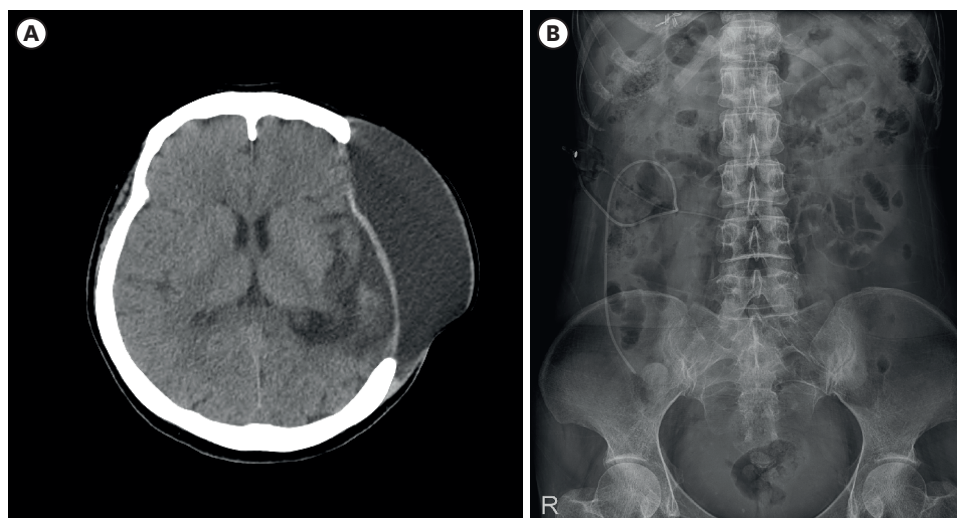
Brain image before lumboperitoneal shunt and postoperative X-ray. (A) Brain computed tomography after three months of craniectomy shows external hydrocephalus in the left hemisphere. (B) A simple abdomen plain X-ray anteroposterior view shows the lumboperitoneal shunt (proximal catheter placed between L3 and L4).
